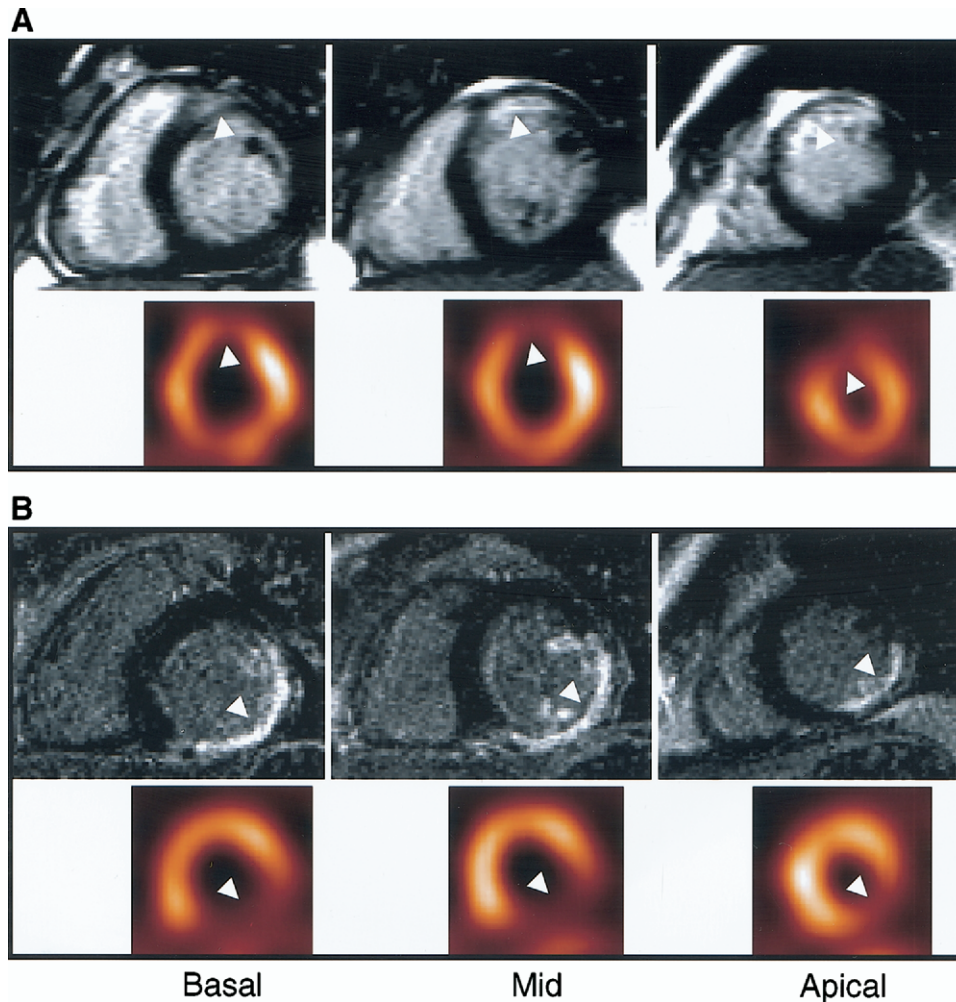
Comparison of CMR and SPECT
